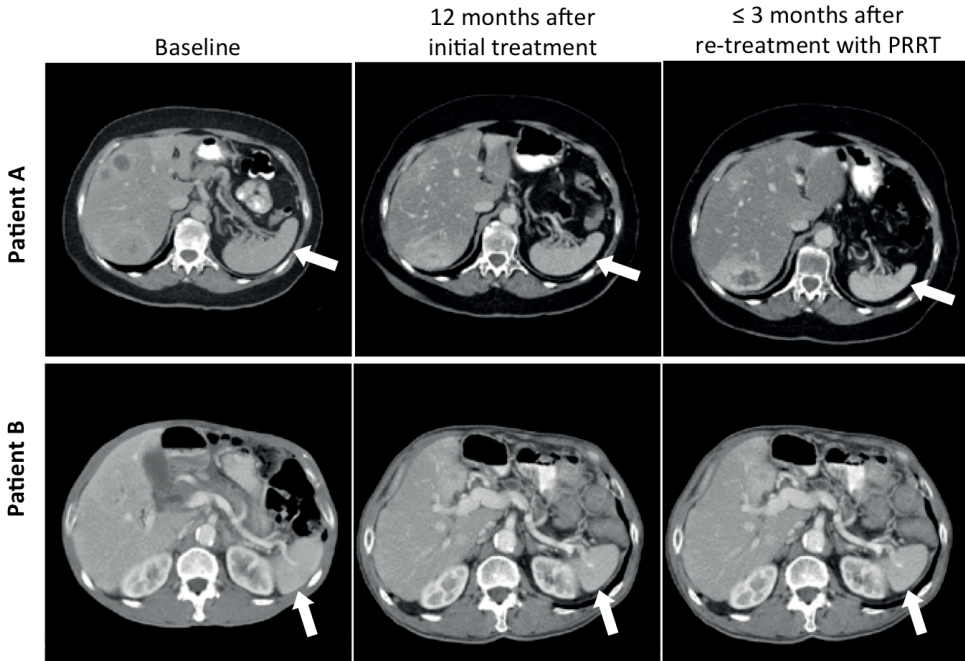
Images of CT-scans in two patients (A & B) at baseline, 12 months after initial treatment and ≤ 3 months after re-treatment with ¹⁷⁷Lu-Octreotate. The spleen (white arrow) appears smaller on CT-scan after multiple cycles of PRRT.
